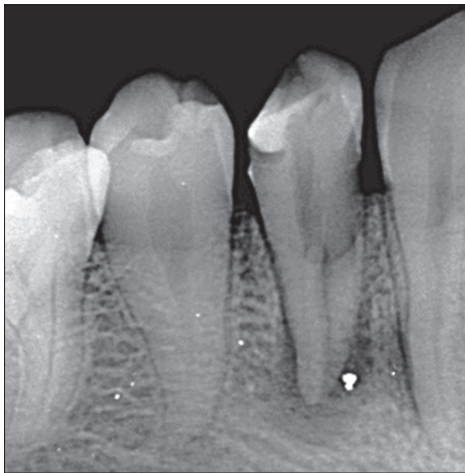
Pre-operative radiograph from mesial angulation depicting the presence of two roots in tooth 34
